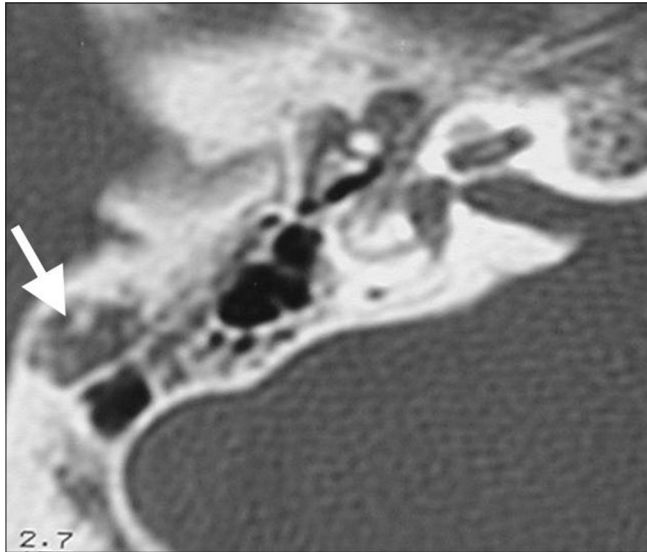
HRCT axial image of right temporal bone shows loss of bony septae (long arrow) resulting in coalescent mastoiditis
